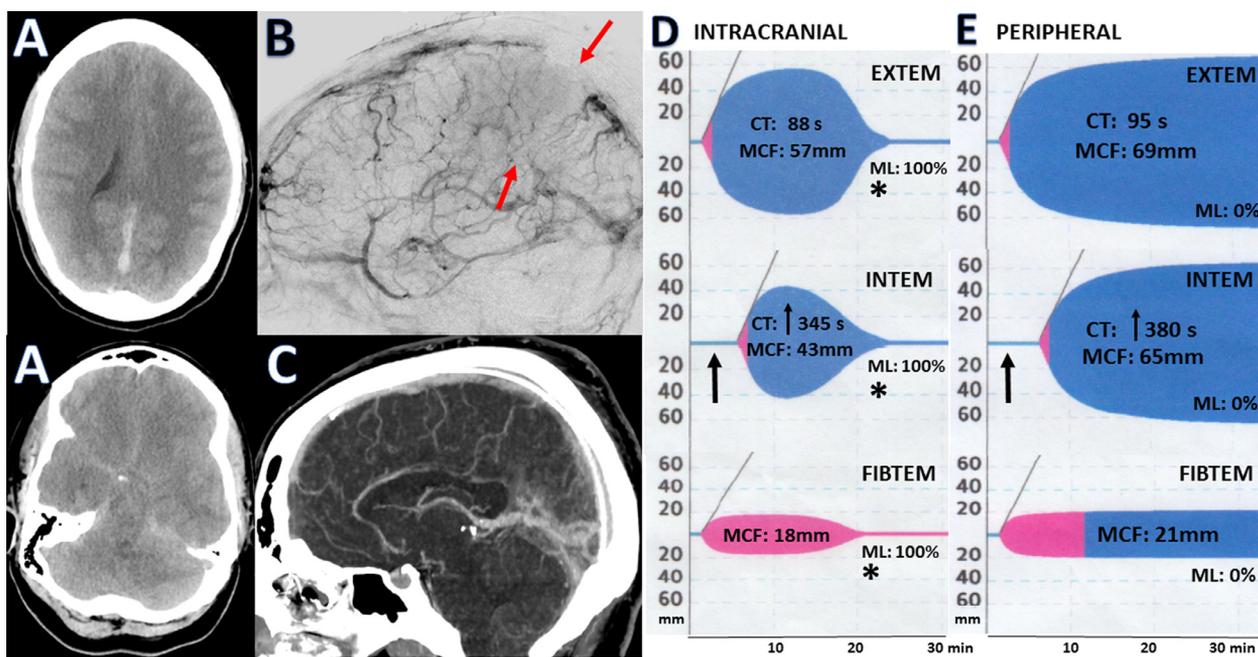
Medically refractory CVST. (A) CVST with edema but no hemorrhage on CT. (B) Angiography revealed extensive CVST with particular burden over superior sagittal and inferior sinus (red arrows) with radiographic resolution on CT-venogram after 40 hours of intracranial-microcatheter tPA infusion (C). Intracranial ROTEM sample 1 hour after tPA cessation revealed ongoing intracranial fibrinolysis (D: tapering amplitude on Y axis; ML: 100%; EXTEM/INTEM-MCF: 57 mm and 43 mm, respectively) not seen peripherally (E: ML0%; EXTEM/INTEM-MCF: 69 mm and 65 mm, respectively). Faster intracranial intrinsic pathway activation coagulation-time was noted (D: arrow; INTEM-CT: 345s) compared to the peripheral sample (E: arrow; INTEM-CT: 380s) suggesting differences in anticoagulation between sites. Color version of figure is available online.
